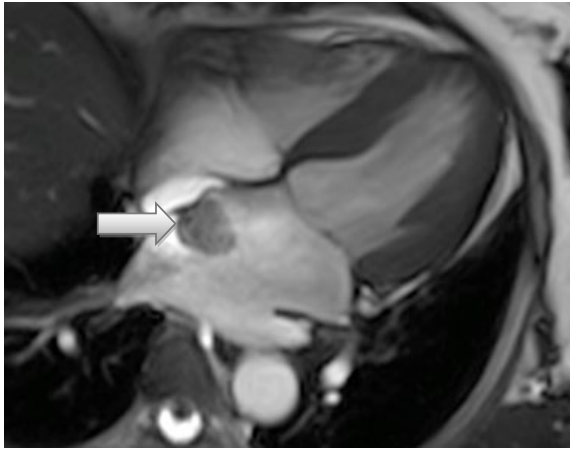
Cine MRI shows a hypointense pedunculated left atrial tumor implanted on the fossa ovalis animated by free motion without prolapsing in the mitral valve.
